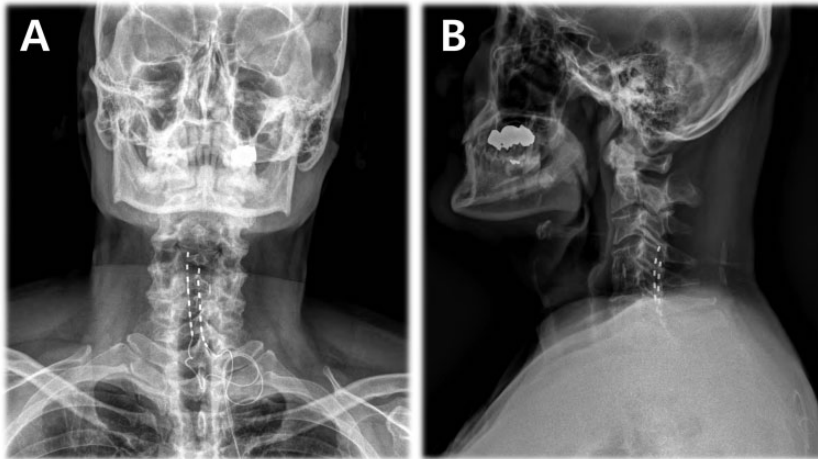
Anteroposterior view (A) and lateral view (B) plain X-rays taken after permanent lead implantation in a 59-year-old male patient (case 1) that presented with severe pain in both upper extremities secondary to a suspected spinal cord injury subsequent to a cervical interbody fusion surgery at C4–C5. He complained of sharp, tingling and scratching pain over 9 years and paroxysmal pain similar to an electric shock lasting approximately 5 min, more than 20 times a day. The procedure successfully advanced another lead at the right side at the C4–C7 levels.
